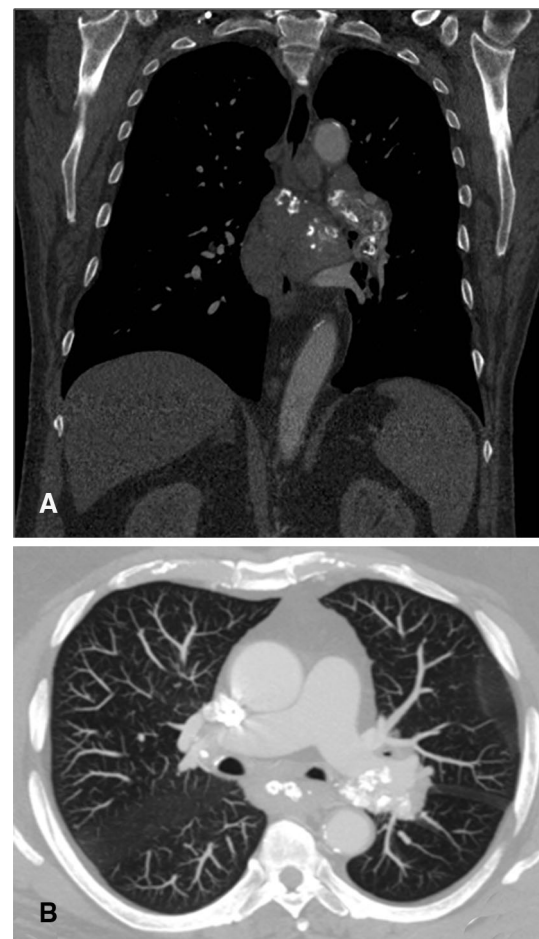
A 53-year-old woman with systemic amyloidosis. Coronal contrast CT image with the mediastinal window setting (a) shows multiple calcified mediastinal lymph nodes. Axial reformatted minimum-intensity projection image at the infracarinal level (b) shows multiple calcified infracarinal and bilateral hilar lymph nodes
